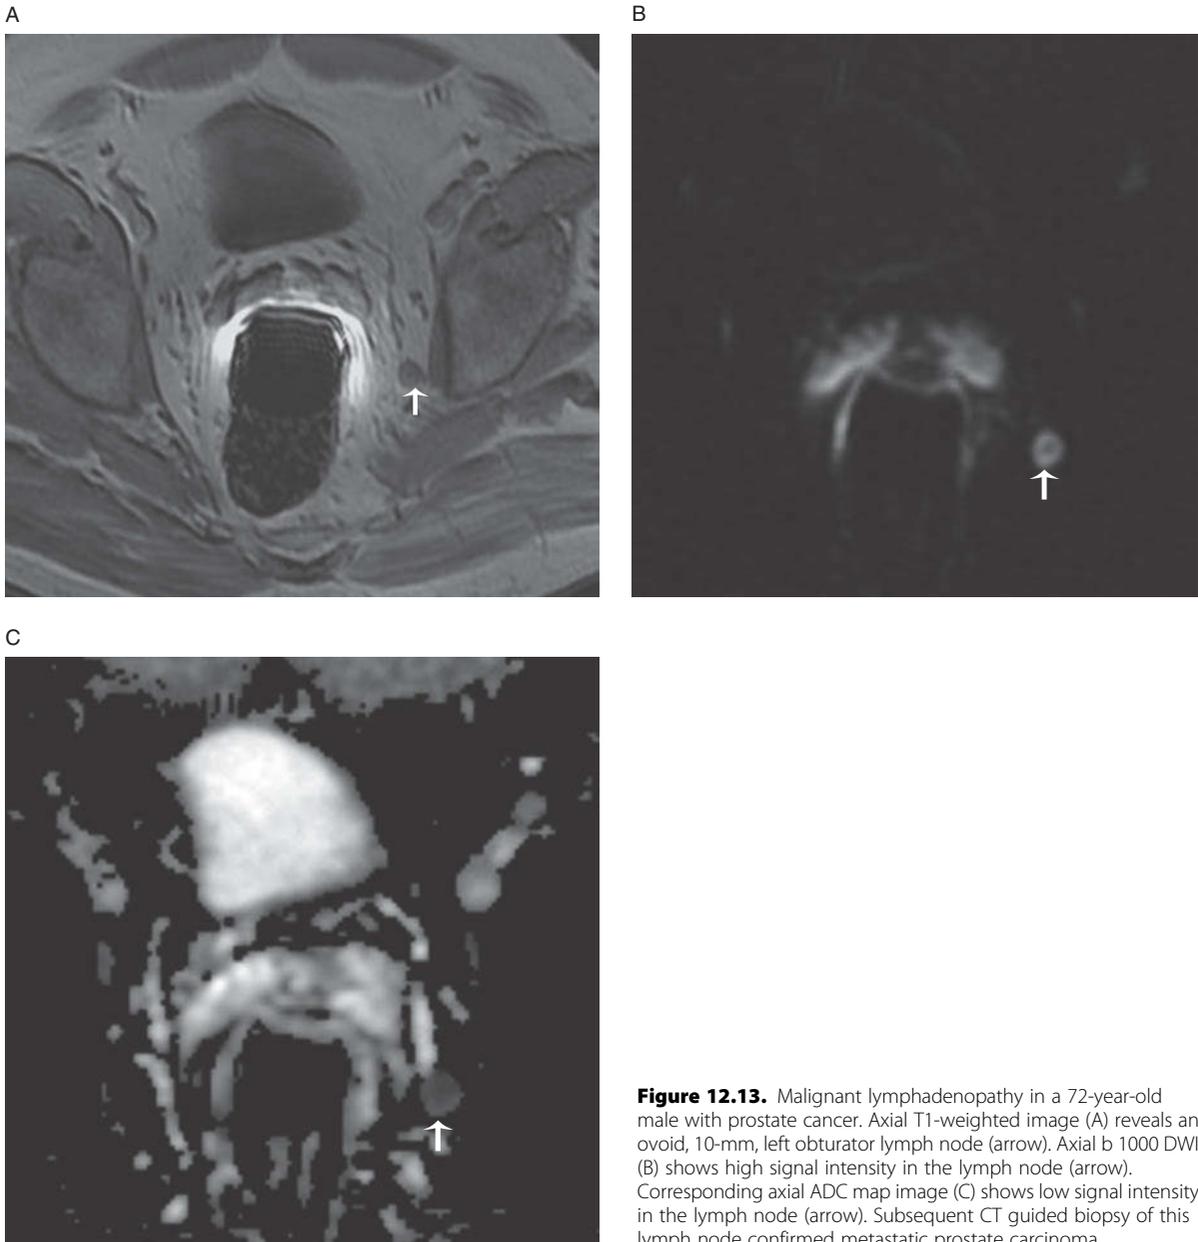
Malignant lymphadenopathy in a 72-year-old male with prostate cancer. Axial T1-weighted image (A) reveals an ovoid, 10-mm, left obturator lymph node (arrow). Axial b 1000 DWI (B) shows high signal intensity in the lymph node (arrow). Corresponding axial ADC map image (C) shows low signal intensity in the lymph node (arrow). Subsequent CT guided biopsy of this lymph node confirmed metastatic prostate carcinoma.
